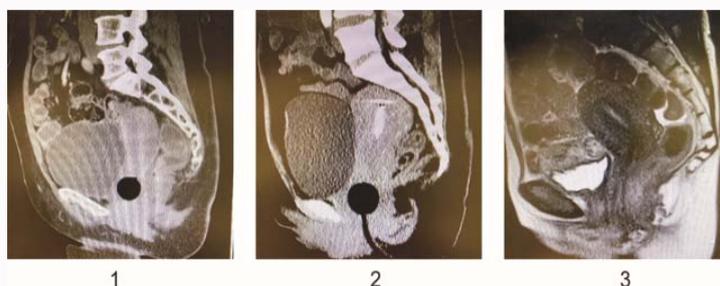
Repeated postoperative imaging results after surgical resection of benign presacral tumors on CT/MRI.
